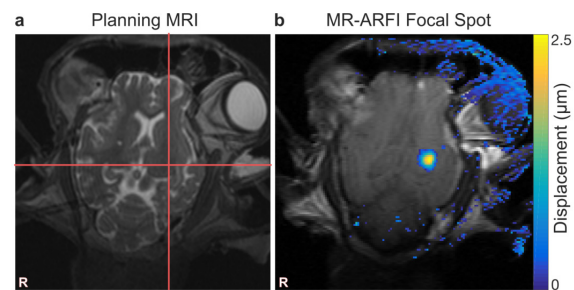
Focal spot targeting and visualization. (a) Prescribed focal spot is indicated by red cross hairs drawn on T2-weighted MRI. (b) Tissue displacement at the focal spot is shown as an overlay on the MR-ARFI magnitude image. Stray pixels in the displacement map outside the brain are artifact due to slight changes between two MR-ARFI acquisitions.
